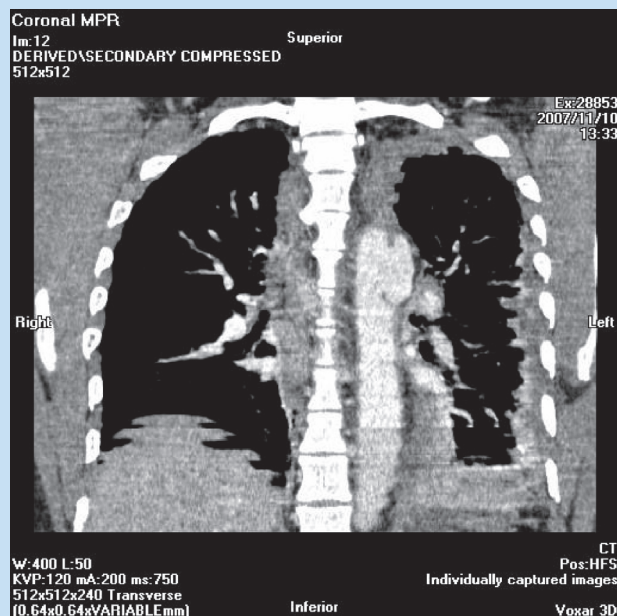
Post-contrast chest CTA (coronal view), demonstrating the pseudo-aneurysm in the distal aortic arch.
